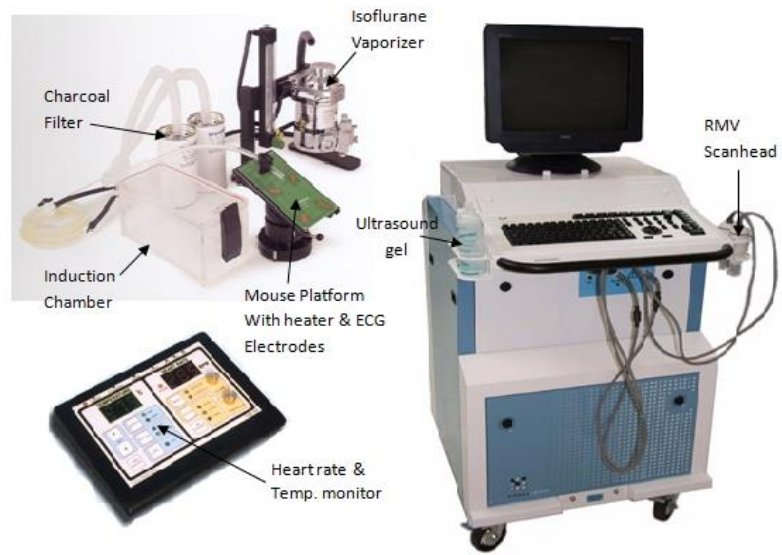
Visual Sonics Vevo 770 ® High Resolution Ultrasound scanner, with the accessory equipment used for trans-thoracic echocardiography
